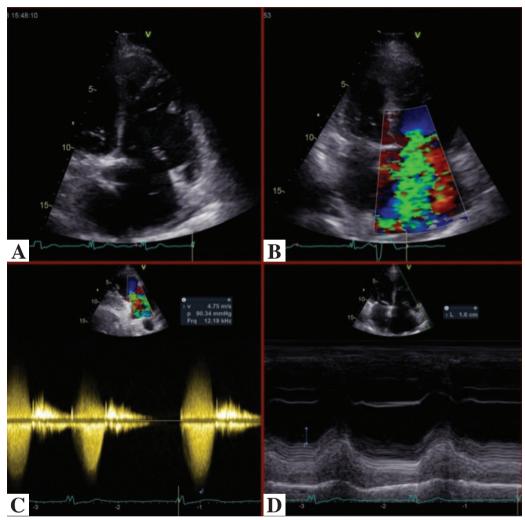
Transthoracic echocardiographic images demonstrating enlarged right-sided cardiac chambers, severe tricuspid regurgitation, severe pulmonary hypertension, and borderline right ventricular systolic function. A. Enlarged right atrium and ventricle. B. Severe tricuspid regurgitation as measured with color Doppler. C. Peak systolic transtricuspid regurgitant flow velocity and gradient consistent with severe pulmonary hypertension (PHT). D. Borderline tricuspid annular plane systolic excursion (TAPSE) (16 mm).
